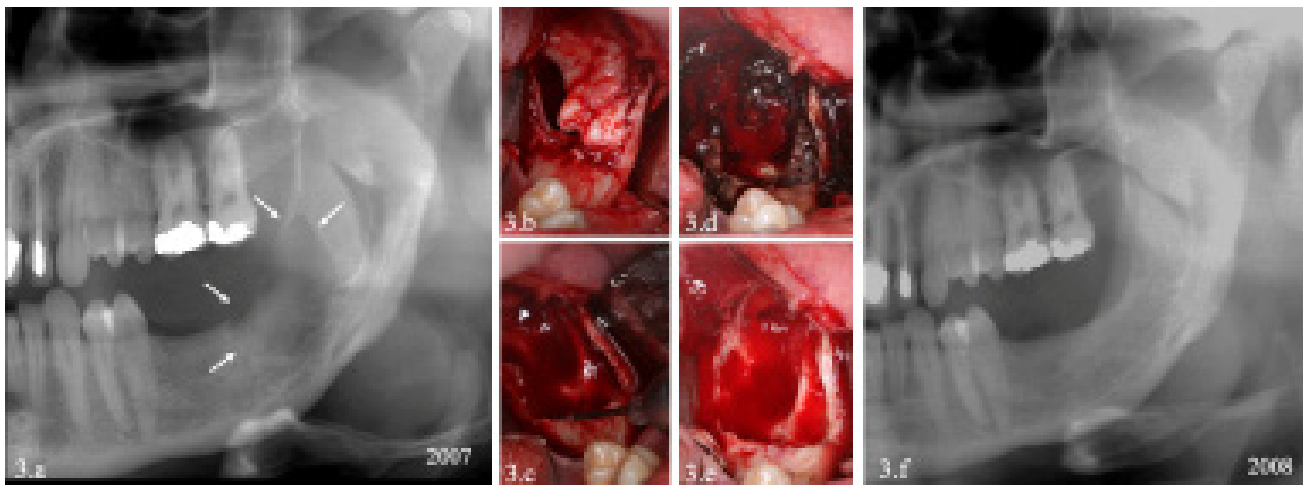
a. Two-years (2007) cropped panoramic radiograph showing the new lesion in the ramus (→). b. Enucleation of the lesion. c. Diode laser application. d. 5-FU application. e. Cavity after cleaning. f. One-year (2008) after third intervention and 6 years after first surgery cropped panoramic radiograph revealing a remission of the cystic lesion.
